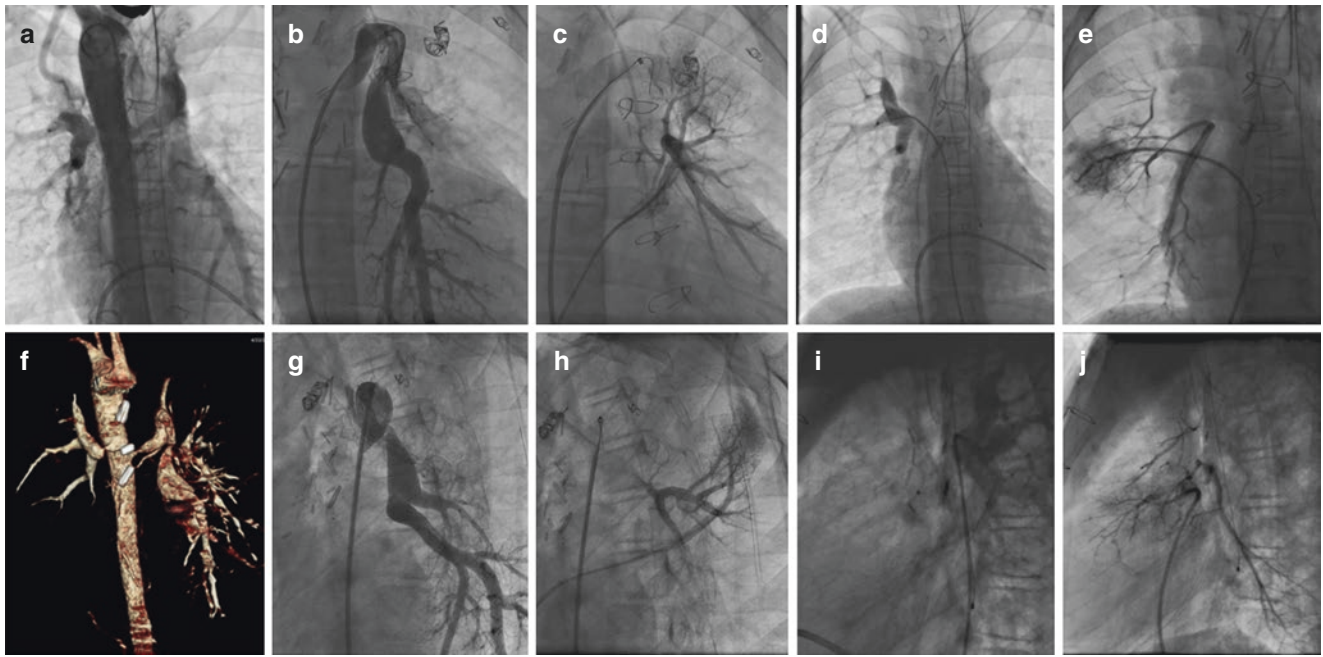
Pulmonary venous wedge injections to delineate the anatomy of vessels that don't have antegrade flow. (a) Anteroposterior projection of aortogram in a patient with TOF/PA/MAPCAs, showing two large APCs from the descending thoracic aorta, one to each lung. (f) shows the same information from a three-dimensional reconstruction from a CTA. In both images there appear to be entire segments of both lungs that are not perfused. (b, g) Injection into the collateral to the left lung shows that it provides flow to medial and posterior segments of the left lower lobe, but no flow to the upper lobe or any anterior segments of the left lung. (c, h) AP and lateral projections of a pulmonary venous wedge injection performed in a branch of the left upper pulmonary vein. Contrast is seen filling the superior segment of the left lower lobe in retrograde fashion. It also fills the lingular branches, all of which are
